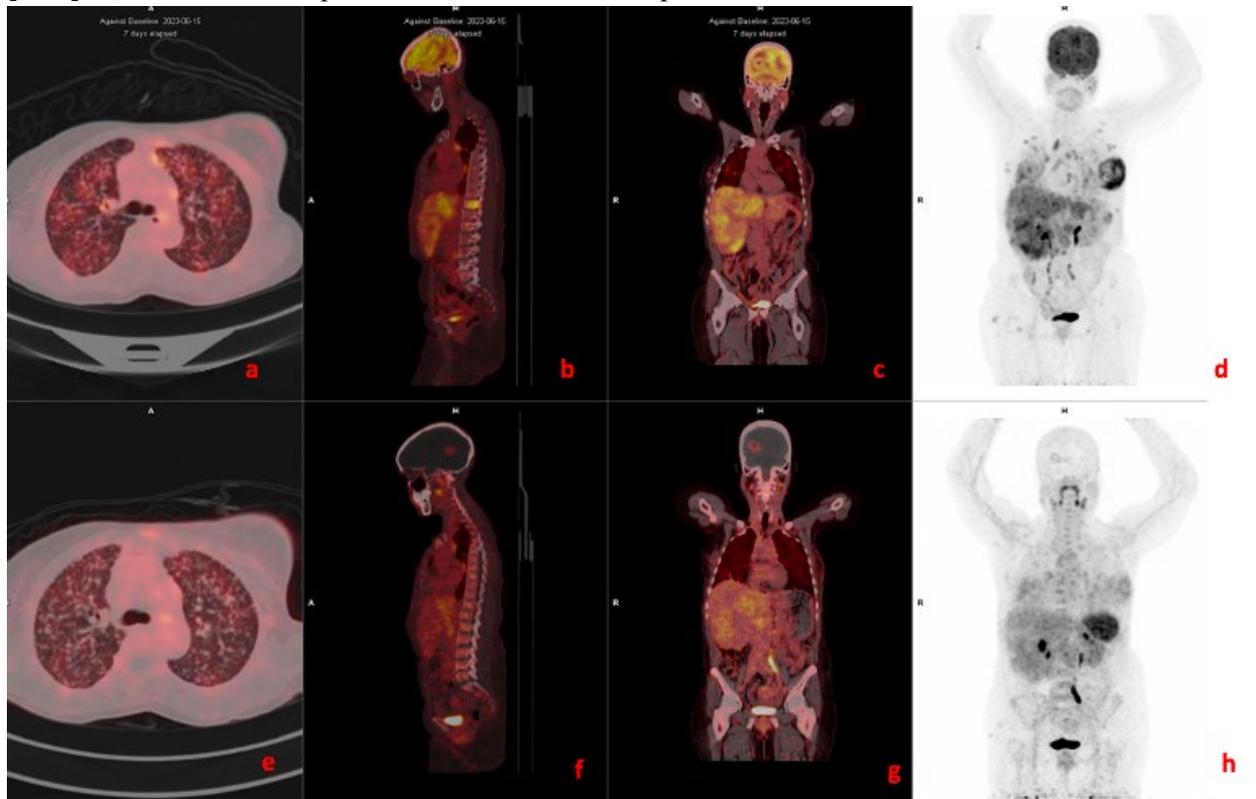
A 41-year-old female with metastatic invasive ductal breast cancer TNBC who underwent [⁶⁸Ga]Ga-PentixaFor (lower panel) and [¹⁸F]FDG PET/CT (upper panel). Axial, coronal, and sagittal fused [⁶⁸Ga]Ga-PentixaFor PET/CT images demonstrated lung (a, e); brain (b, f), bone (b, f) and liver (c, g). The brain and liver metastases which were more clearly visualized on [⁶⁸Ga]Ga-PentixaFor compared to [¹⁸F]FDG PET/CT whereas the metastasis to the vertebra were clearly visualised on [¹⁸F]FDG PET/CT and missed [⁶⁸Ga]Ga-PentixaFor.
